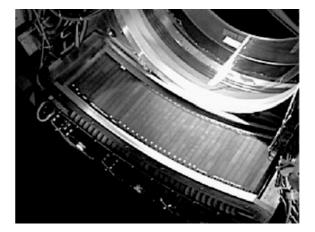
Prototype of a CT area detector providing 256×0.5 mm collimation (from: Mori et al. (2006))
